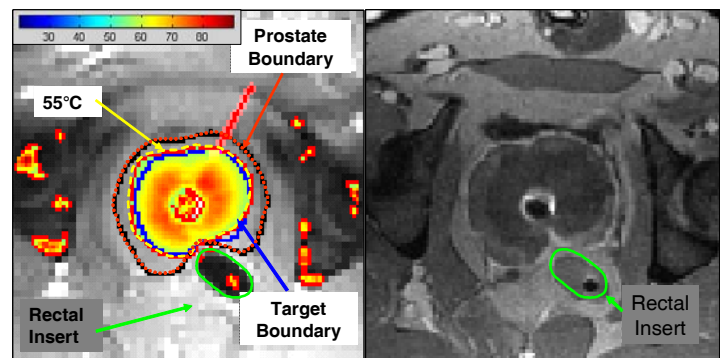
(left) Maximum temperature distribution measured during treatment superimposed on the prostate and target boundary. (right) Contrast enhanced MR image acquired after treatment depicts the region of thermal damage.
